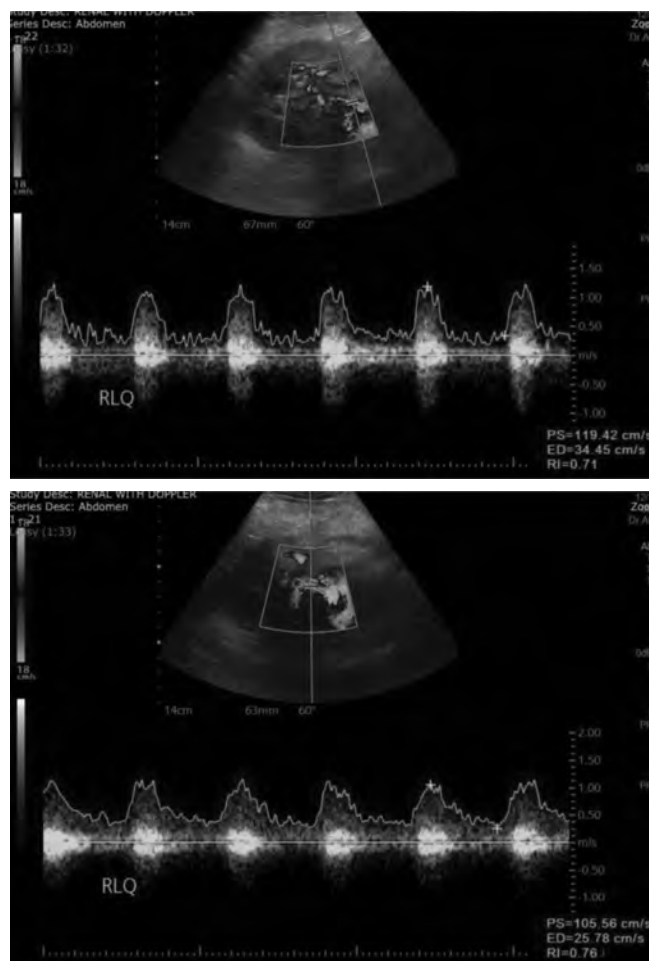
Renal power doppler ultrasound of allograft kidney
